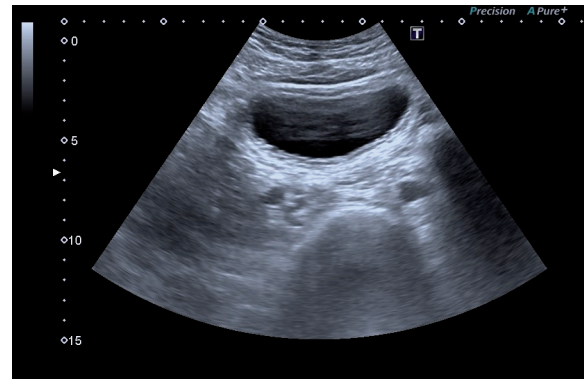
In the transverse sonographic plane, the bladder wall was not smooth and was trabeculated
